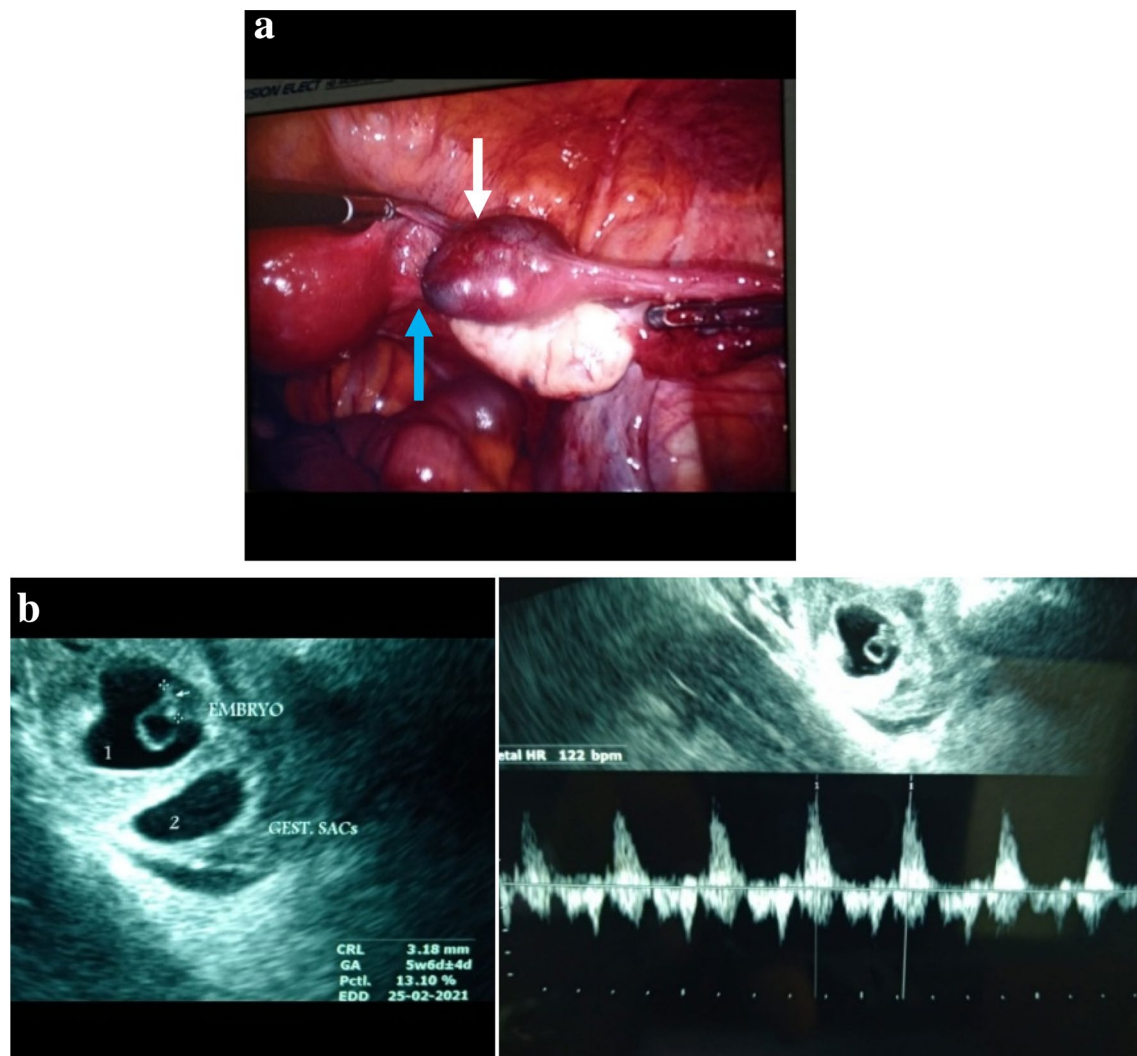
a Laparoscopic Findings: Ectopic pregnancy (arrow: scar rupture) within the right tube showing (two gestation sacs) b: TVS showing two gestation sacs within right fallopian tube; Doppler Study (TVS) showing cardiac motion of the first fetus
